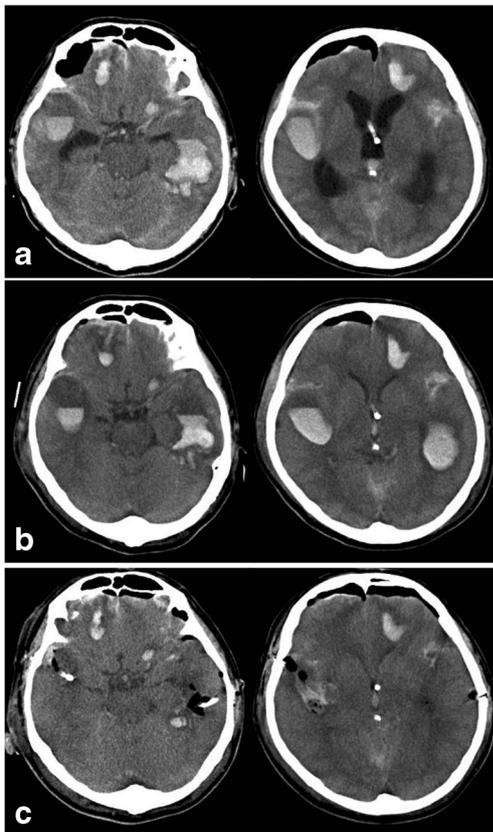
CT scans of case 10, a 58-year-old man with fall accident. a CT scan taken the next day of trauma revealed manifestation of multiple cerebral contusions in his bilateral temporal lobes and bilateral frontal lobes. He underwent ventricular drainage for acute hydrocephalus. b CT scan taken 2 days after trauma, showing increased contusional edema. The blood-fluid interfaces were observed in contusions. Lateral ventricles were collapsed with the increasing intracranial pressure to 30 mmHg. c Postoperative CT scan revealed the disappearance of the blood-fluid interfaces in both temporal lobes, with the successful reduction of intracranial pressure under 10 mmHg
